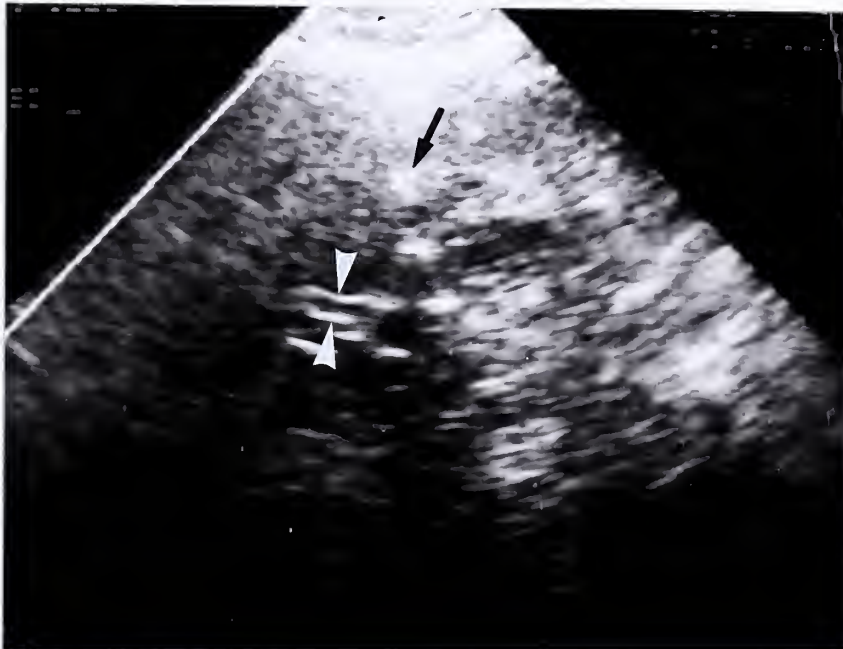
Subject #2: Ultrasound images showing (A) a small contracted gallbladder containing stones [echogenic focus (arrow) with prominent acoustic shadowing (S)]; and (B) a normal common bile duct (arrowheads), and air in the intrahepatic ducts (arrow).
